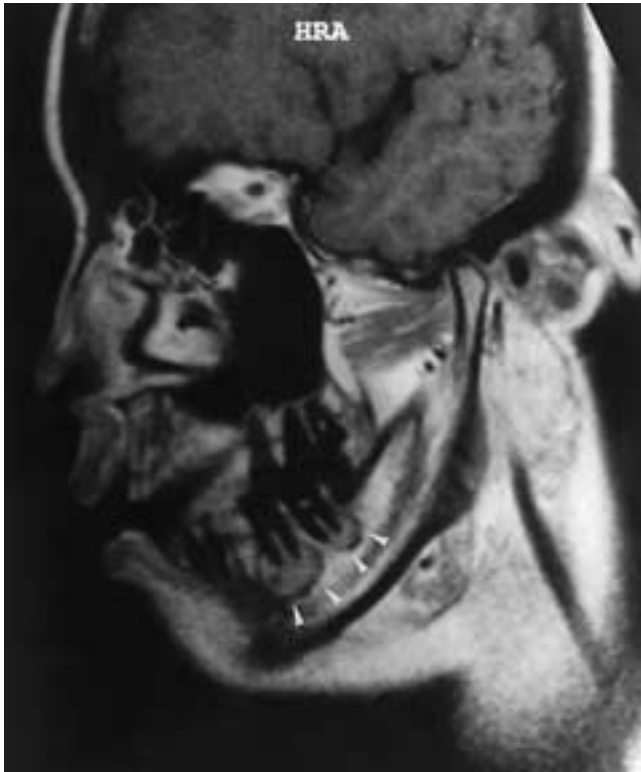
Cemental dysplasia of the mandible in a 38-year-old woman. Oblique sagittal T1-weighted MR image reveals multiple low signal intensities with tiny signal voids in the periapical region (arrowheads). Preoperative diagnosis of cemental dysplasia is made by radiography, and MR imaging is not useful for differentiation.
